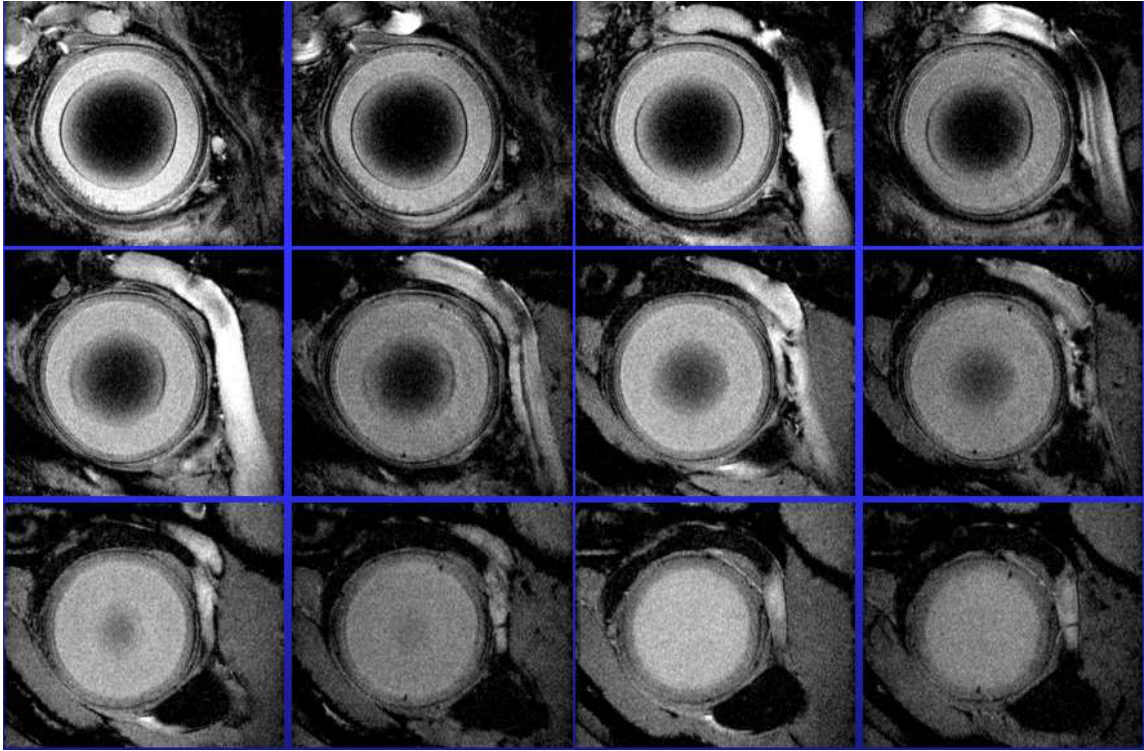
Image from PSU High Field MRI Lab; Gradient echo, TR 200 ms, TE 8.56 ms, matrix size 192 X 264, FOV 6 X 8 mm, 16 averages, Texp 10.6 min, in-plane resolution 30 X 30 micrometers, slice thickness 100 micrometers
